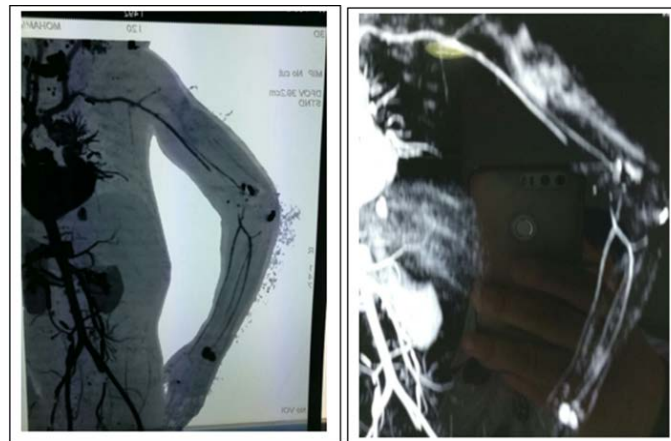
Brachial artery injuries in multislice CT-A, (Lesions \geq 5 mm).
